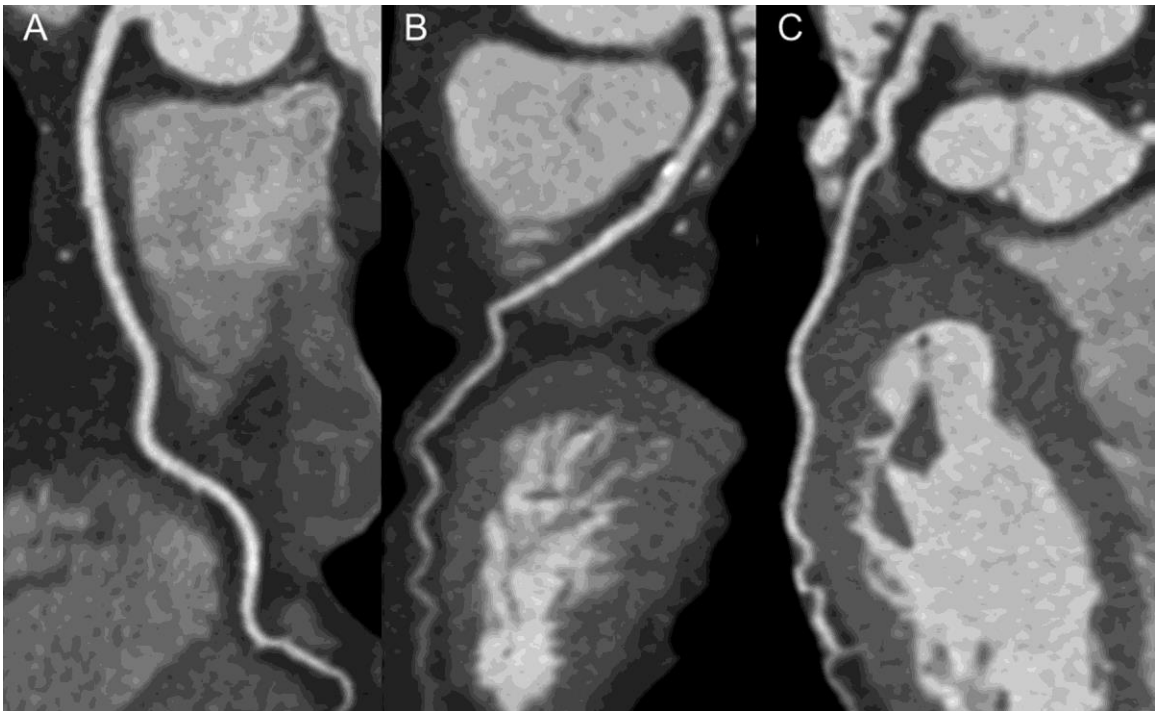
Coronary CT angiogram is used for diagnosing coronary artery disease. [4]
